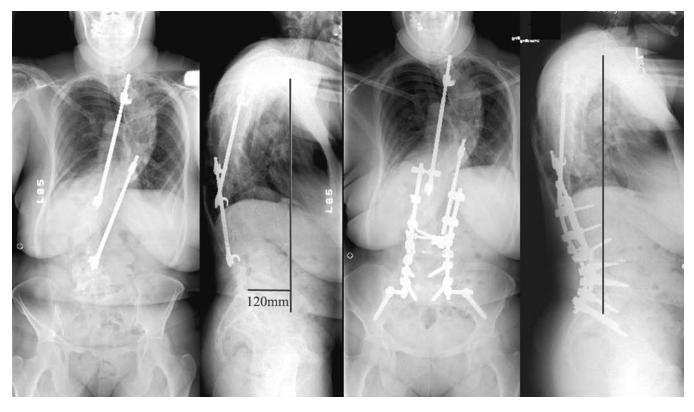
Standing AP and lateral films of a patient with severe and progressive LIS, and a history of fusion. (A,B) AP and lateral preoperative long-cassette plain films. (C,D) Postoperative view of construct with correction of sagittal imbalance and improvement of lumbar curve.
